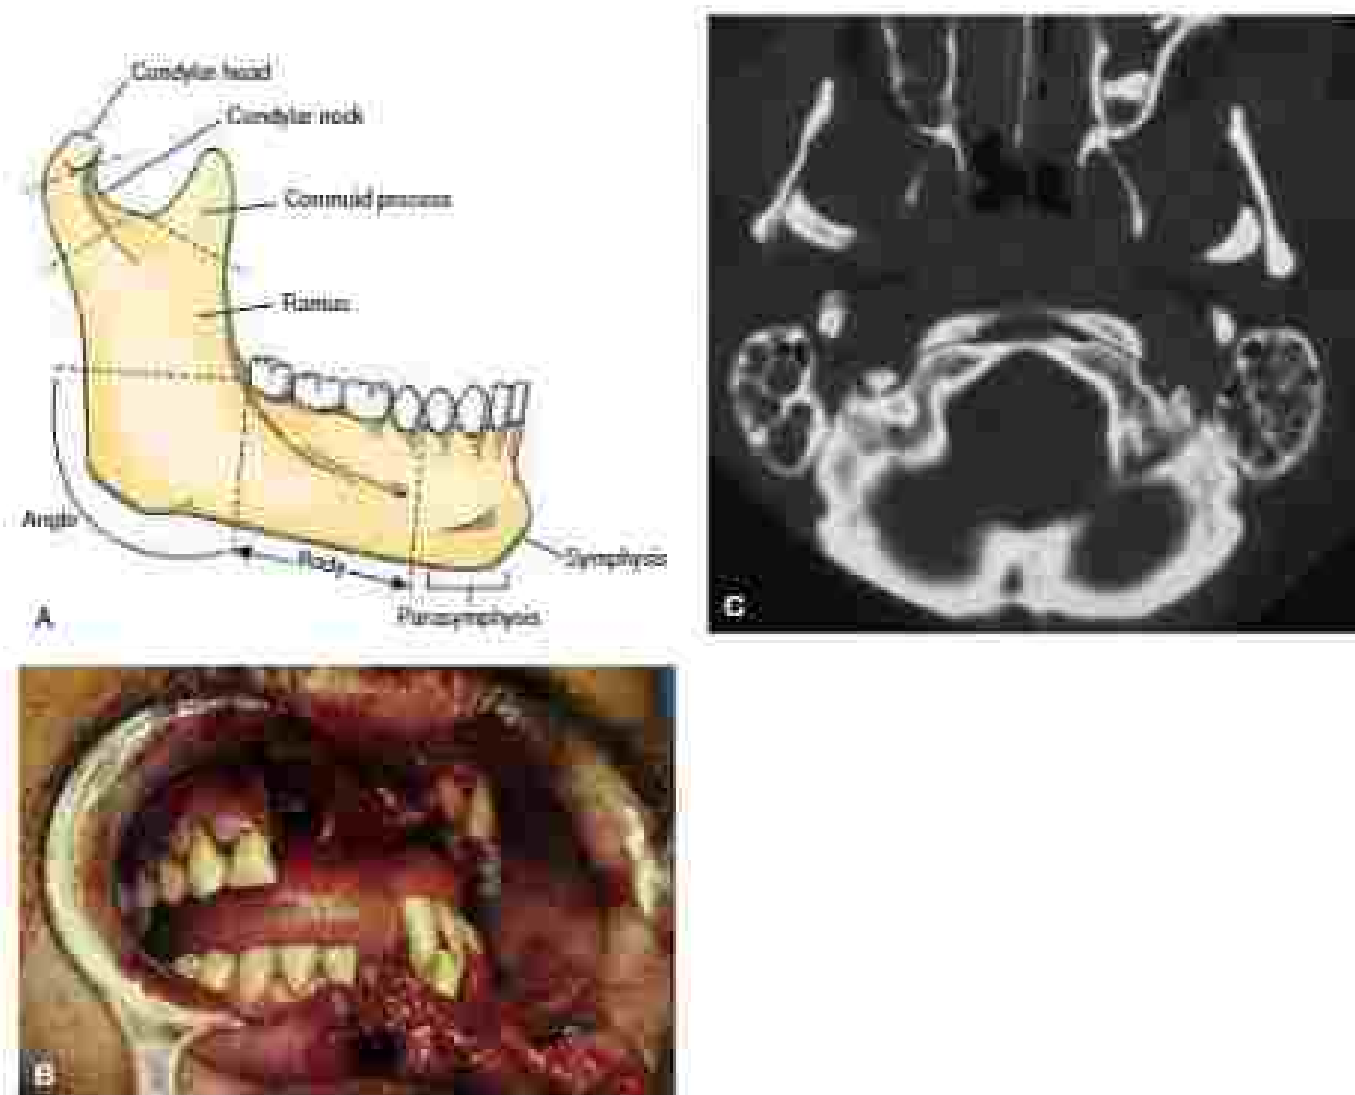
(A) The anatomic regions of the mandible include the condylar and subcondylar areas and ramus posteriorly, the angle and the body laterally, and the symphysis and parasymphysis areas anteriorly. Weak areas are the subcondylar region, the angle, weakened by the third molar teeth, and the parasymphysis area, weakened by the ling root of the cuspid tooth. (B) A patient with anterior mandible, hemimaxillary fractures, and a Le Fort I maxillary fracture. Computed tomography scan of (C) bilateral subcondylar and symphysis fractures of the mandible.
